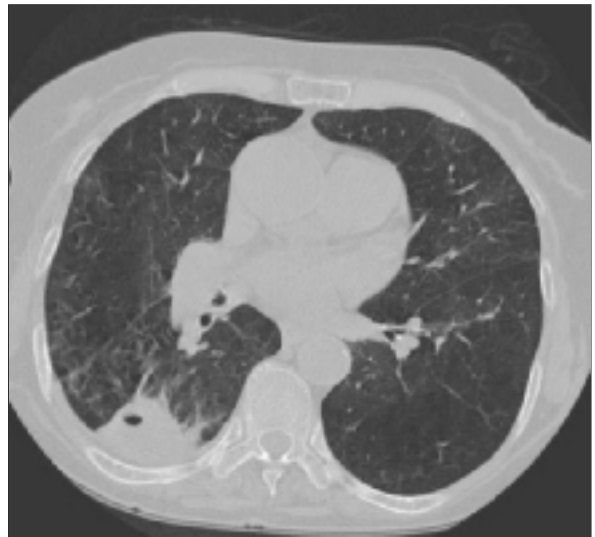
Chest computed tomography, a pleural based mass lesion with irregular margins and a central cavitation in the lower lobe of right hemithorax.
